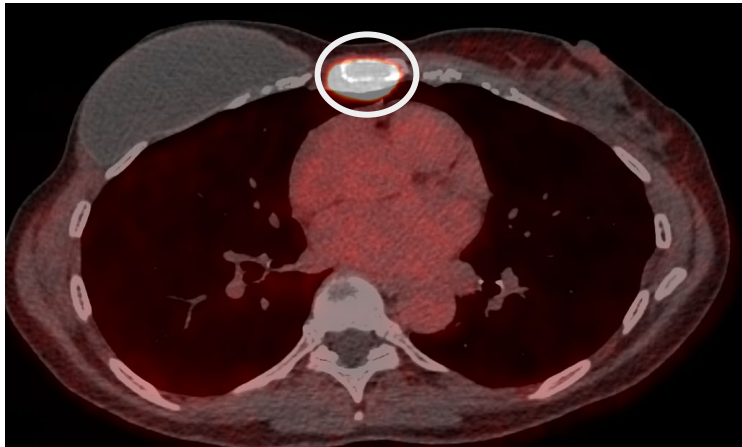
Fused axial PET/CT image of a different patient (left) demonstrates intense tracer uptake within the sternum (*white circle*) corresponding to the site of biopsy-proven osseous metastatic disease. The maximum intensity projection (MIP) image (right) shows this lesion (*black circle*).
